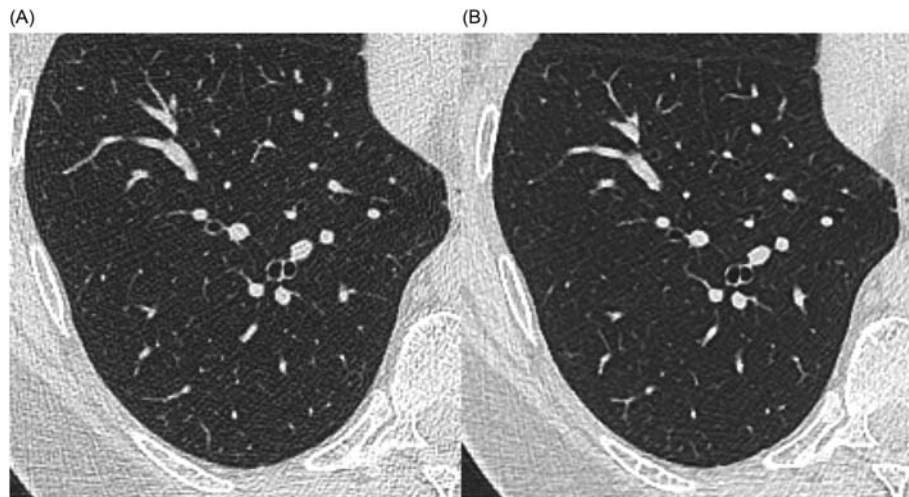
CT of the lung reconstructed with standard filtered back projection (A) and raw data-based iterative reconstruction (B). Note the reduced noise artifacts on the iteratively reconstructed images. Iterative reconstruction can be used either to generate images with less noise, or to lower the tube current (and thereby the radiation dose to the patient), ending up with the same contrast-to-noise ratio as it would be with standard filtered back projection in combination with standard tube current.
